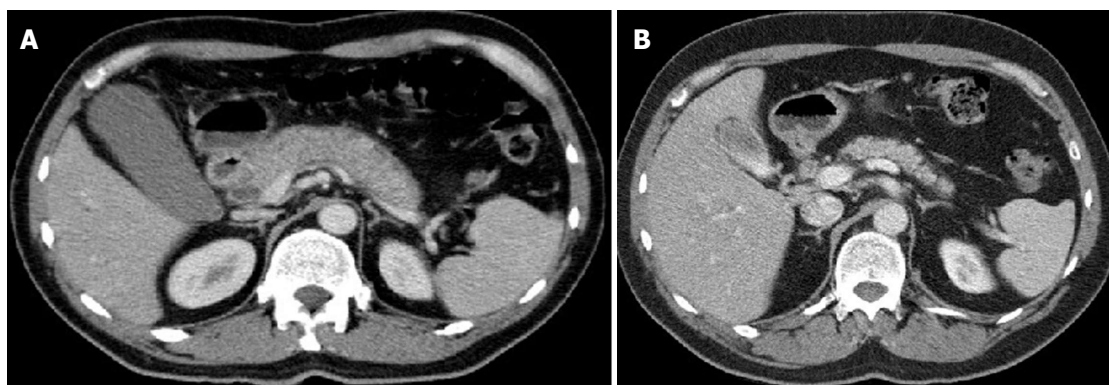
Axial computed tomography image. A: Demonstrating a characteristic sausage shaped enlarged pancreas with surrounding halo in keeping with autoimmune pancreatitis; B: From the same patient 8 mo later following corticosteroid therapy demonstrating response to treatment.
